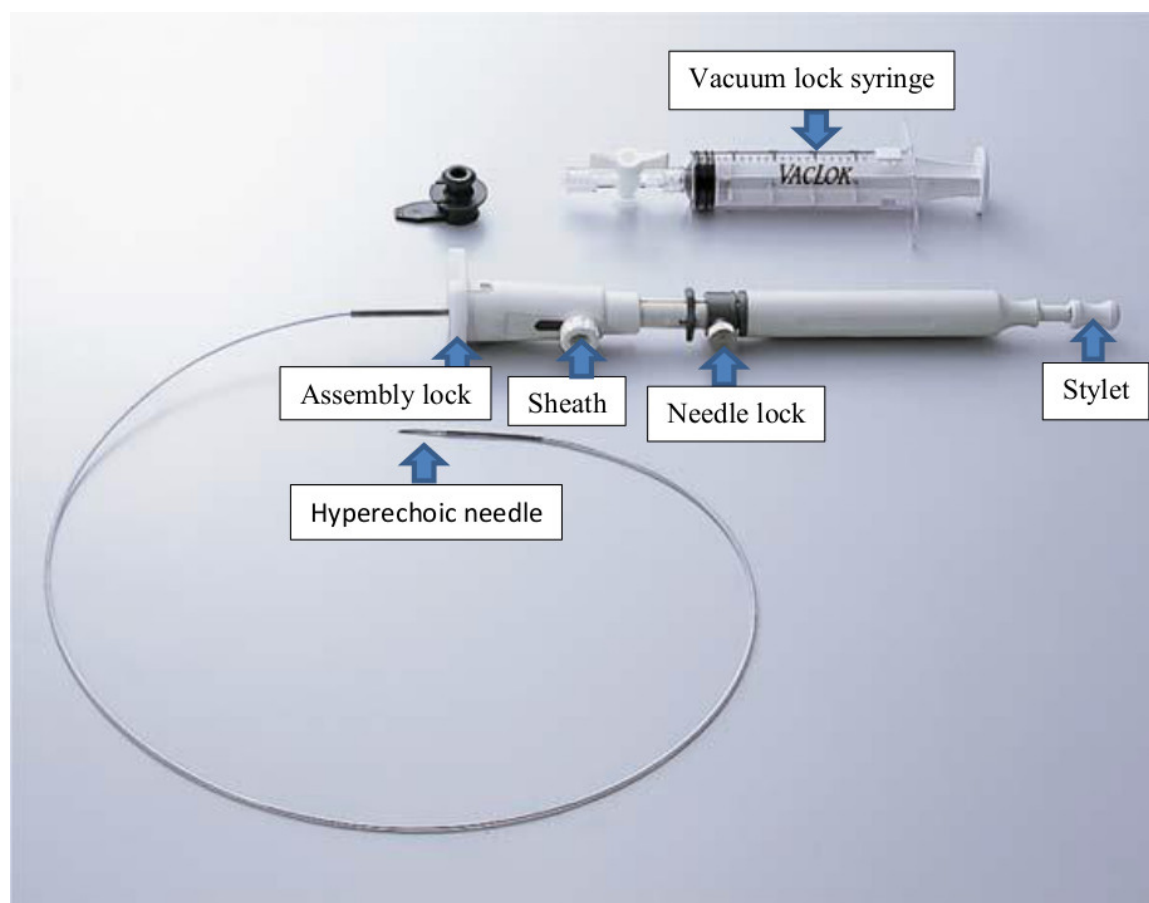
Needle assembly for Endobronchial Ultrasound-guided Transbronchial Needle Biopsy.
